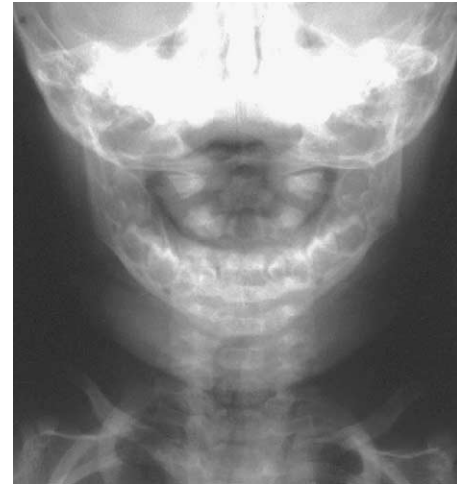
A common situation with regular morphology and a shift of C1 to the right. In this case the radiograph helps verify the clinical tests, as we would expect a right-convex posture in this child.
